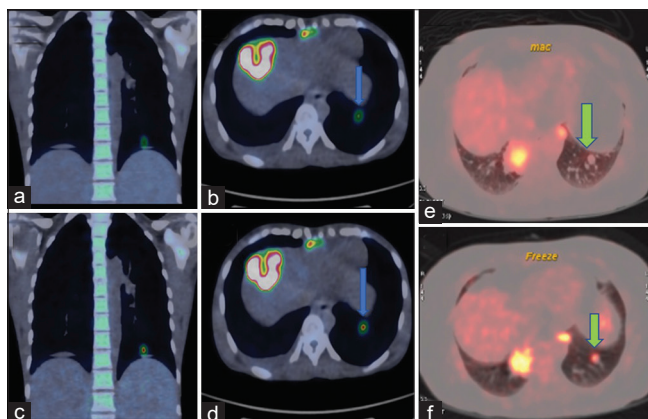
(a and b) Nongated coronal and axial images of the left lung nodule appear blurred (arrow). (c and d) Gated images – the lesion is better delineated with increased SUV (arrow). (e) Nonavid left lung nodule near diaphragm on nongated image shows avidity on the gated image (arrow) (f)
